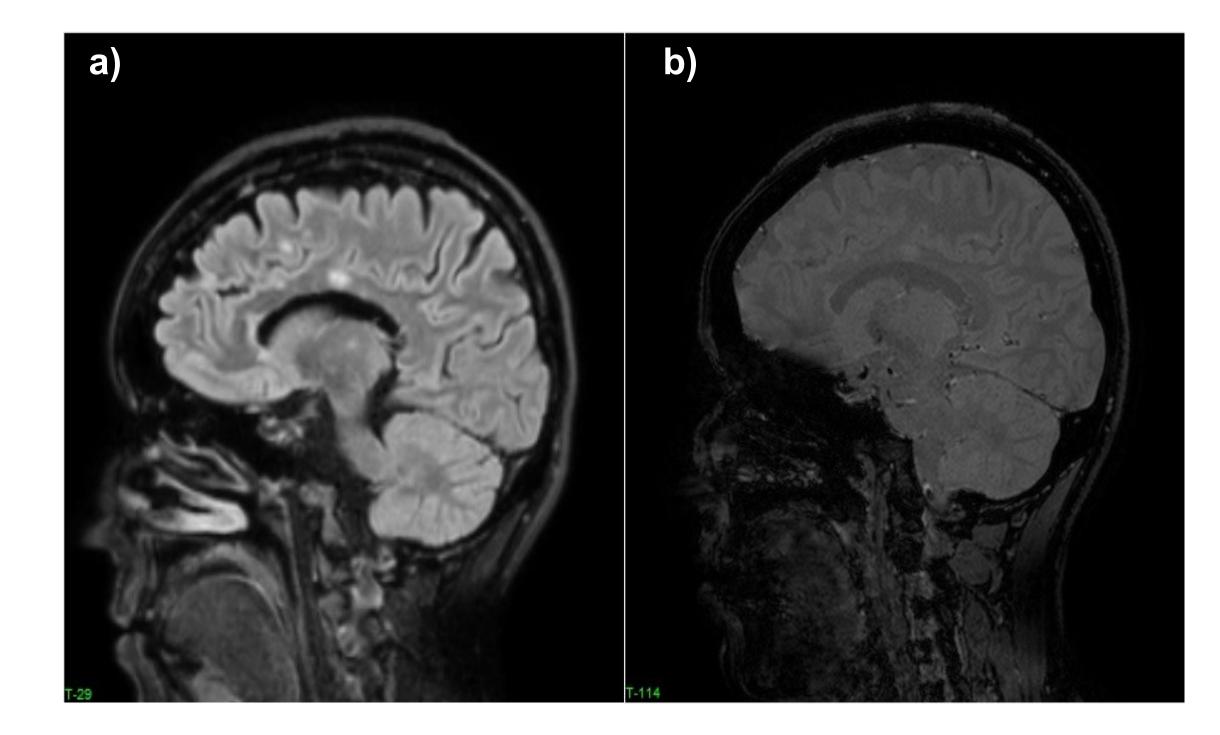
Lesions hyperintense on FLAIR without central vein sign on SWI. a) Sagittal FLAIR MRI scan showing pericallosal and juxtacortical lesions. b) Sagittal SWI MRI scan showing how these lesions do not present the central vein sign.
